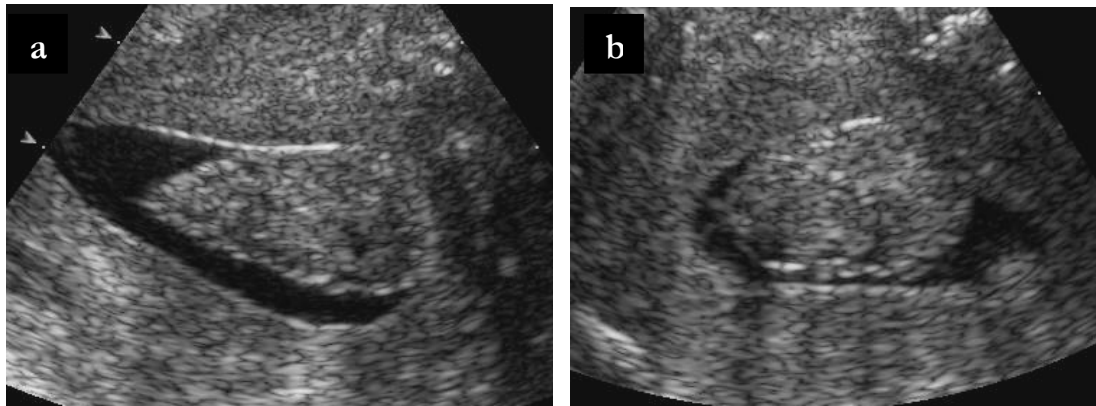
(a) hydrosonography, longitudinal sonogram; (b) hydrosonography, transversal sonogram
